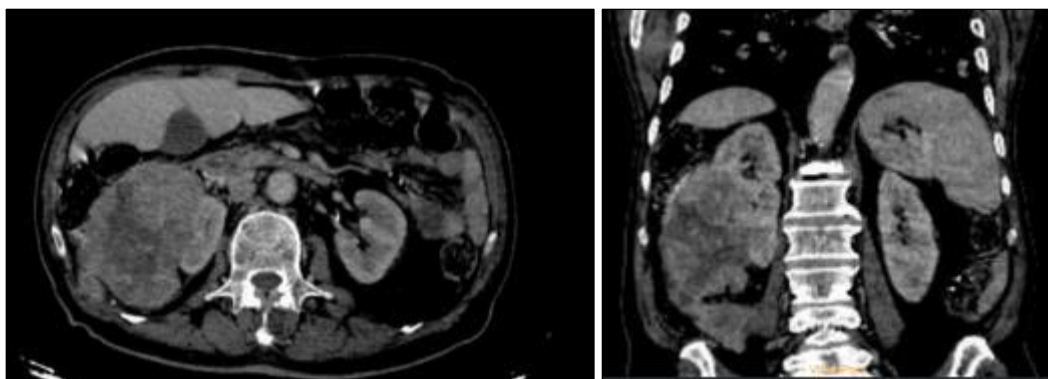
CT scan showing the large heterogeneous right renal mass.
